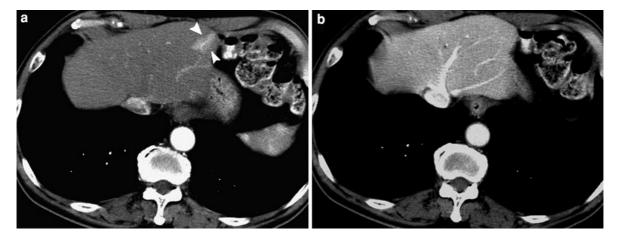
Transient hepatic attenuation difference. a Arterial phase CT scan shows a triangular-shaped hyperenhancing lesion (*arrowheads*) with central enhancing vascular structure
